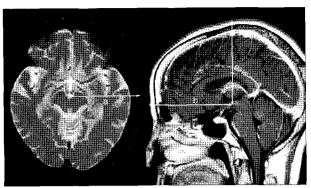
The a, b and c which are required for equation (2) can be measured from the preexisting MRI. The center of the head is the junction between the mammillary bodies and the brain stem, which is the landmark for measurements.
